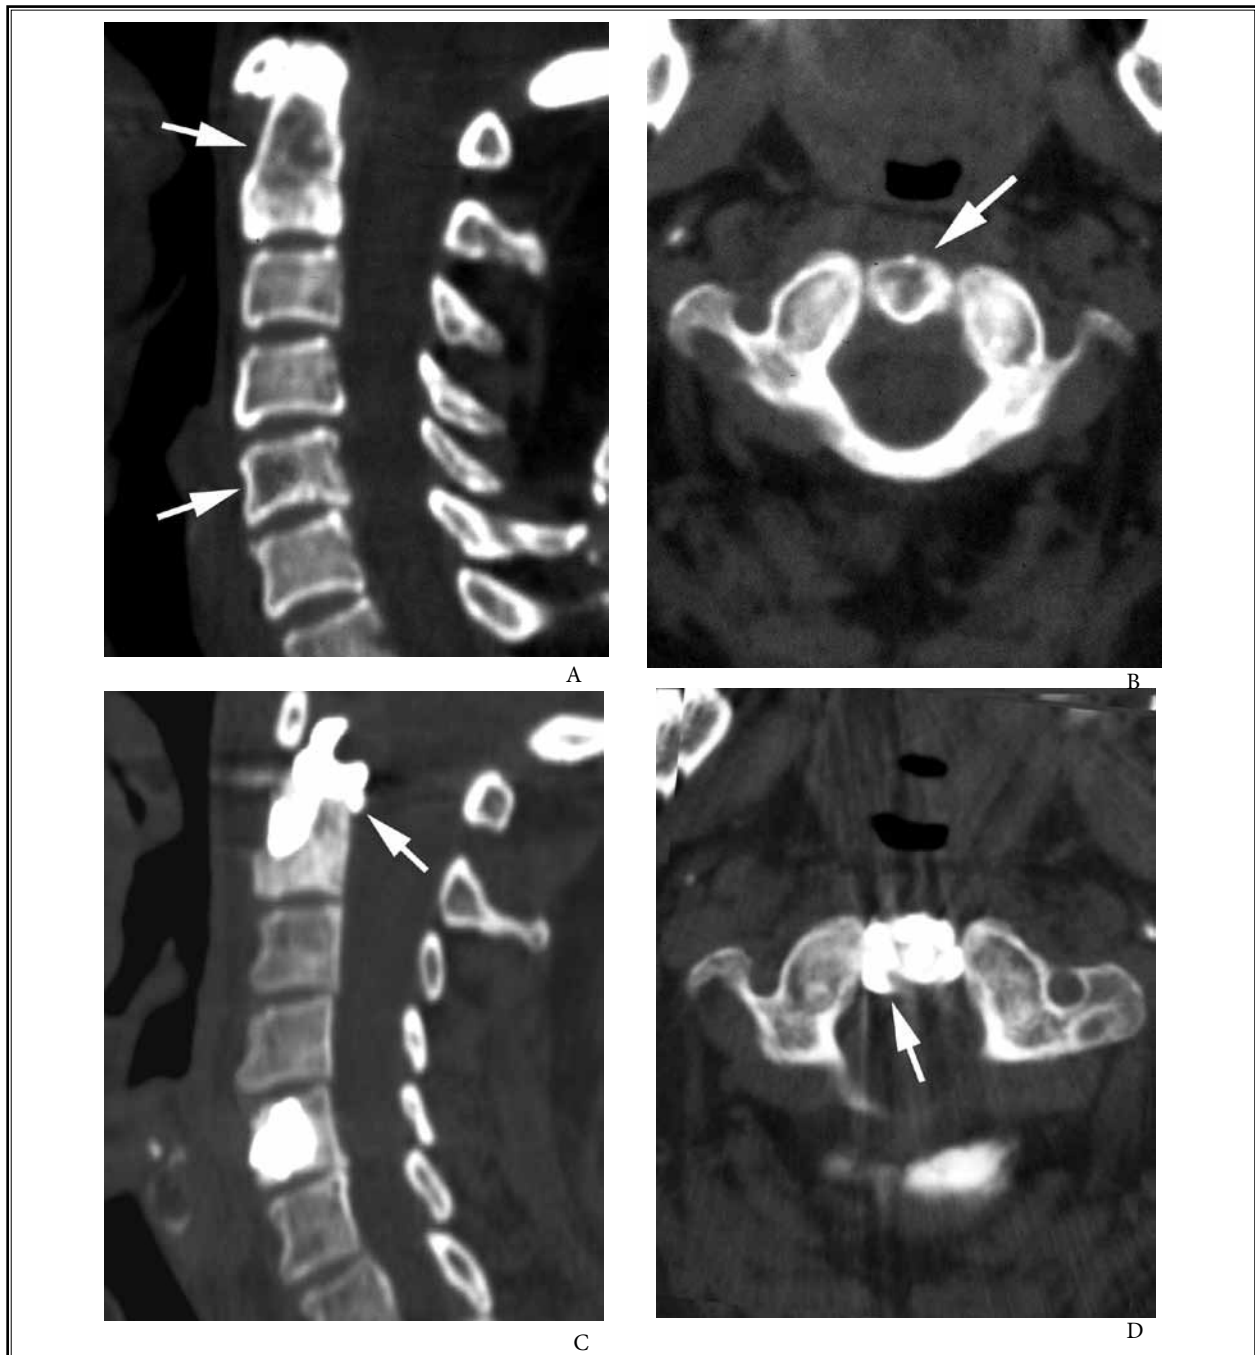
Pre- and post-operative sagittal and axial CT images of the upper cervical spine. Pre-operative sagittal (a) and axial (b) CT images show osteolytic lesions in C2 and C5 (arrows). Post-operative sagittal (c) and axial (d) CT images show satisfactory cement distribution over the osteolytic lesion in the body of C2 and cement leakage in the anterior epidural space (arrows). Satisfactory cement filling in C5 osteolytic metastases is also seen.
